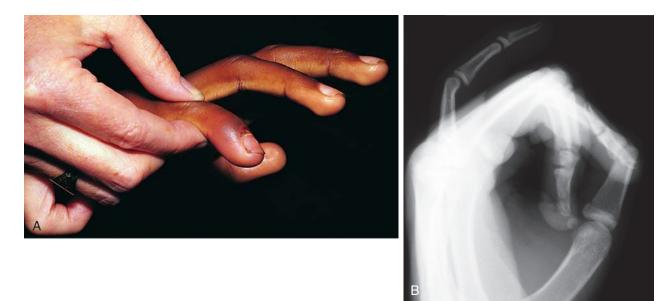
Distal phalanx fracture with extensor tendon injury. A, Another player's shoulder landed on this boy's finger. The finger was swollen and painful and maximally tender at the base of the distal phalanx, and the patient was unable to extend the distal interphalangeal joint. B, Radiograph revealed separation of the epiphysis at the base of the distal phalanx.
